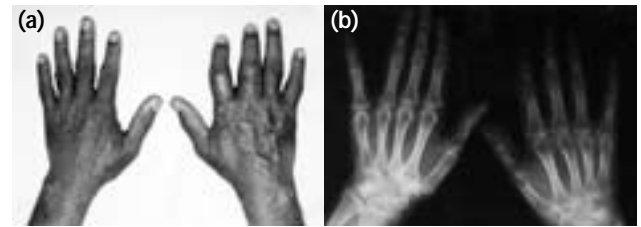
Complex regional pain syndrome of the right hand: (a) clinical characteristics and (b) anteroposterior radiograph showing periarticular osteopenia and patchy demineralisation of the bone.
